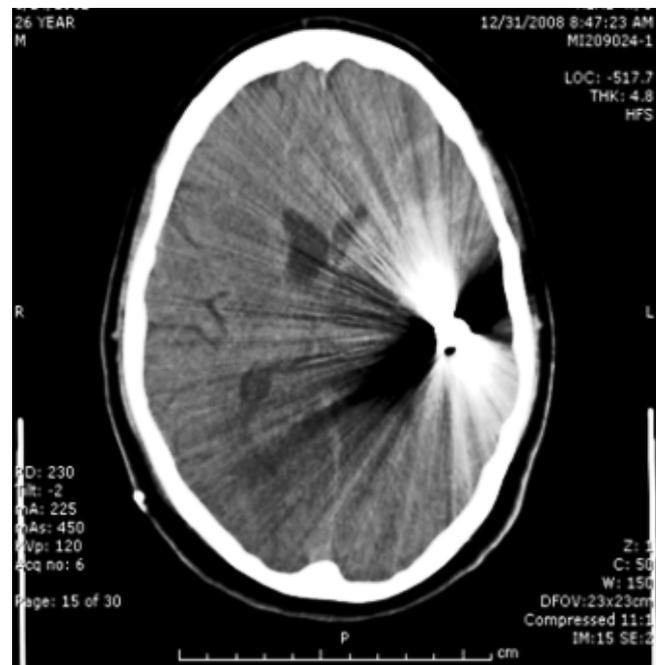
Head computed tomography scan without contrast showing large bullet fragment with metallic artifact in the left fronto-temporal lobe with edema surrounding the left periventricular region.
